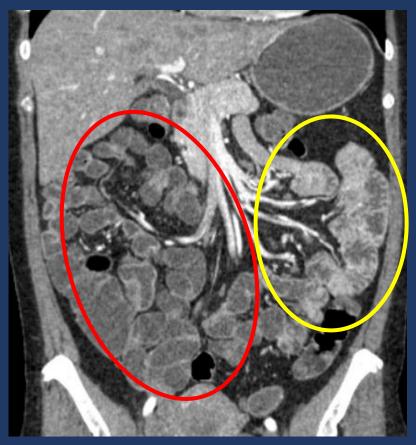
Coronal CT enterography showing the normal aspect of the small bowel. Note that jejunal loops (yellow circle) have more valvulae conniventes than ileal loops (red circle).
